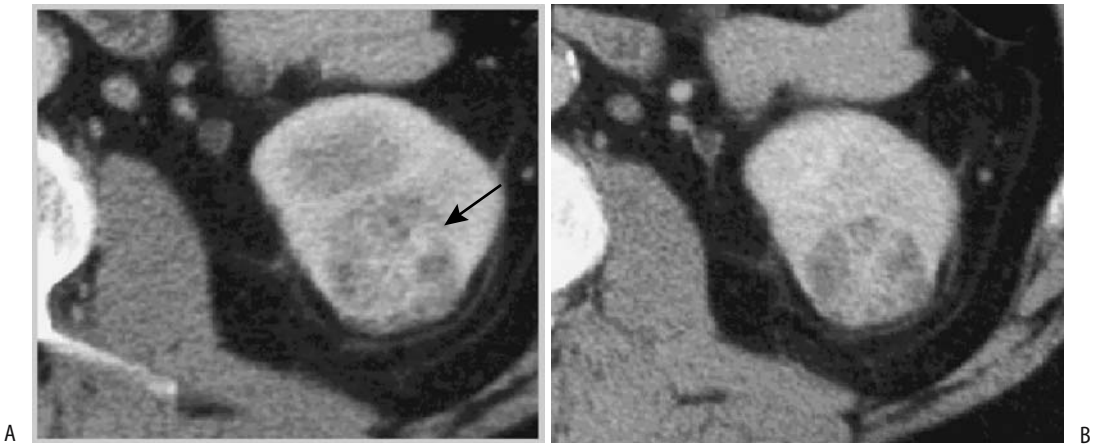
Clear cell renal cell carcinoma. A: Corticomedullary phase CT shows a heterogeneously enhancing tumor (arrow.) B: Nephrographic phase CT better defines tumor. (Source: Szolar DH, Kammerhuber F, Altziebler S, et al. Multiphasic helical CT of the kidney: increased conspicuity for detection and characterization of small (<3 cm) renal masses. *Radiology* 1997;202:211–217, with permission from the Radiological Society of North America.)
